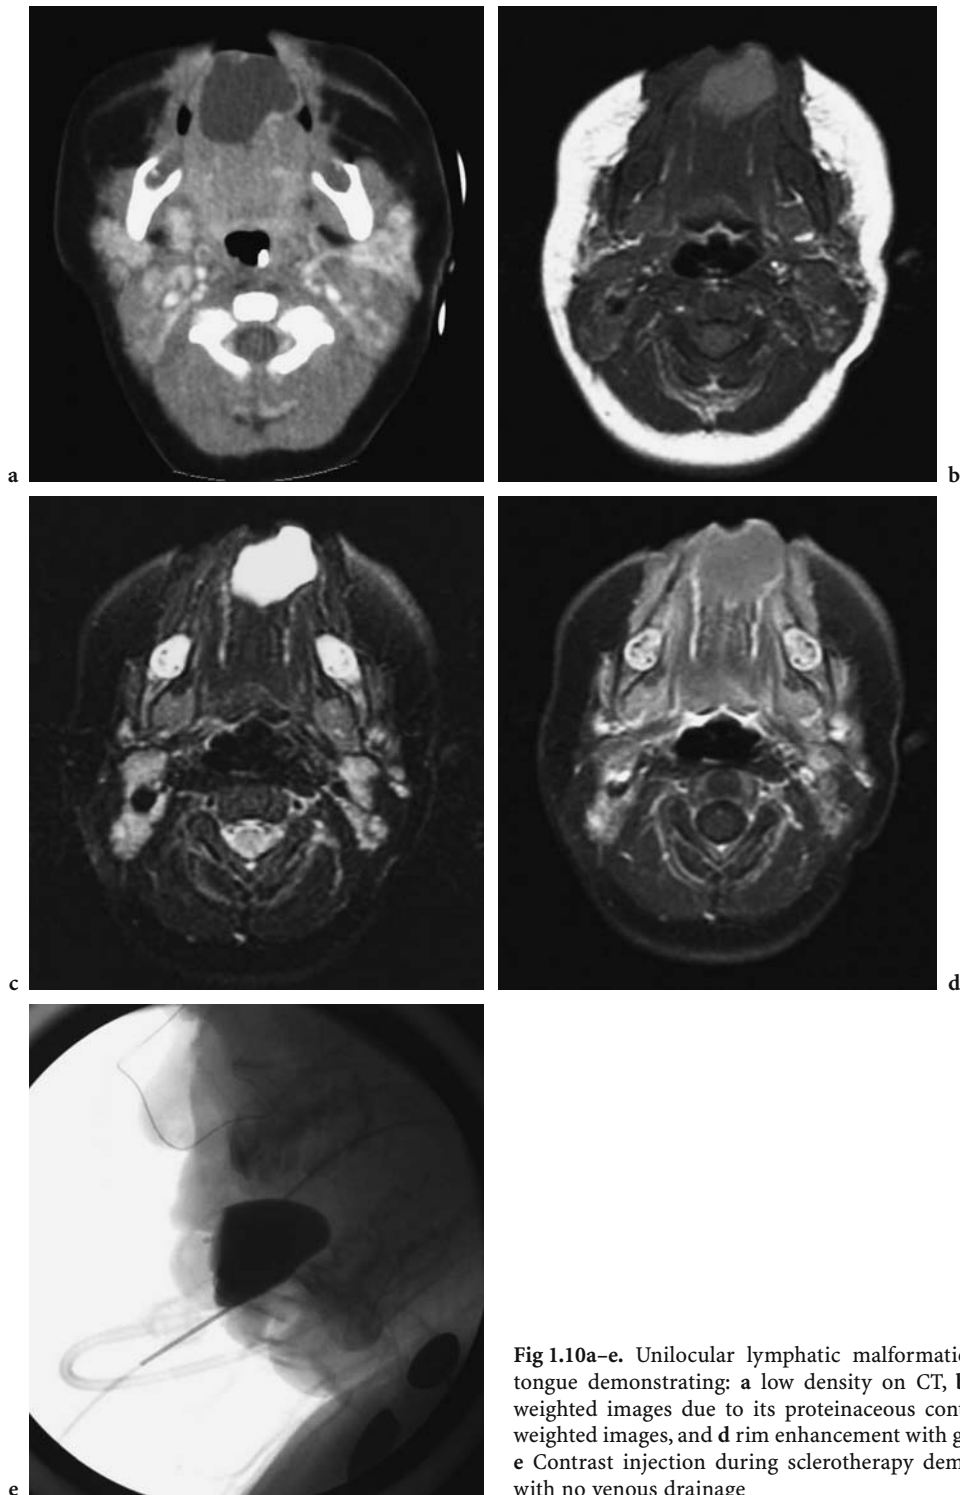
Unilocular lymphatic malformation involving the anterior tongue demonstrating: a low density on CT, b increased signal on T1-weighted images due to its proteinaceous content, c high signal on T2-weighted images, and d rim enhancement with gadolinium administration. e Contrast injection during sclerotherapy demonstrating a single cavity with no venous drainage
